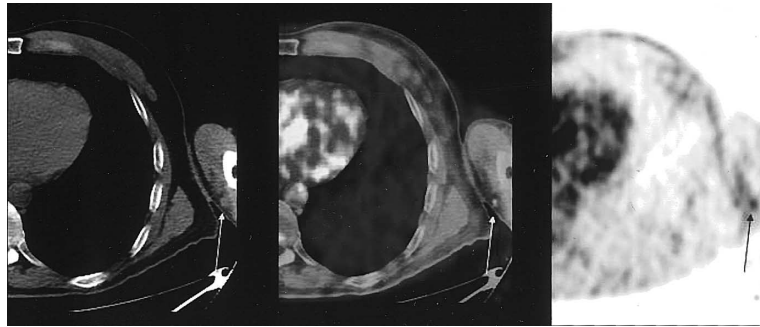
Moderate FDG activity in the left basilic vein on PET-CT (SUVmax 2.95). Note also moderate activity in myocardium.
